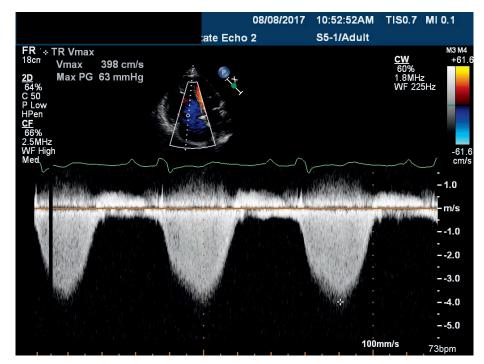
Continuous wave spectral Doppler demonstrating severe pulmonary hypertension.
